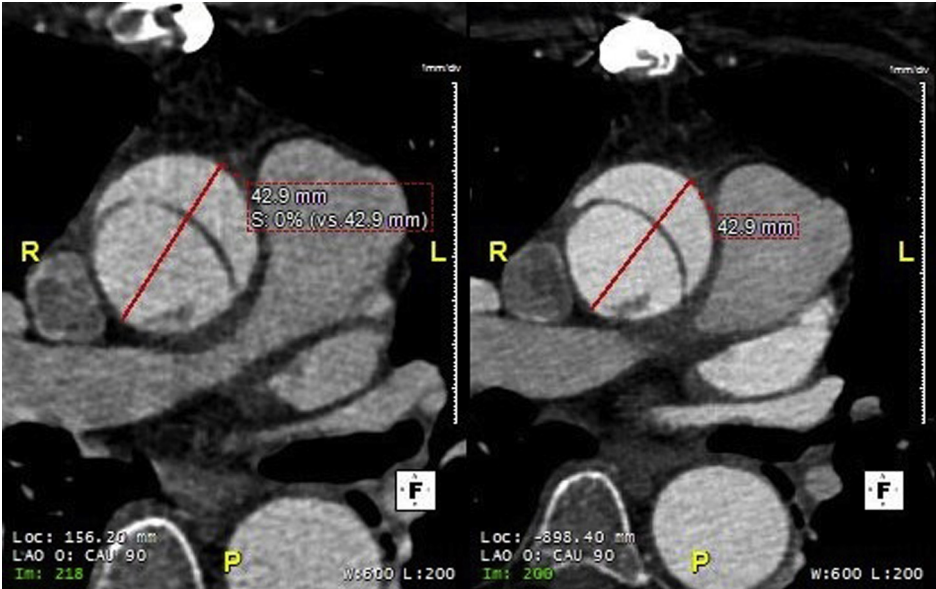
Axial computed tomography angiography images of the aorta at 9 (left panel) and 13 (right panel) months post-operatively demonstrating stable pseudointimal Dacron graft dissection.
